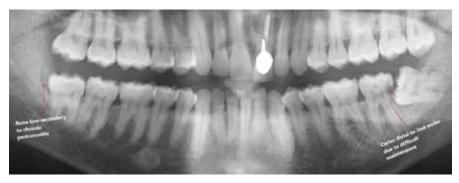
Panoramic radiograph showing possible pathological sequelae of third molars
